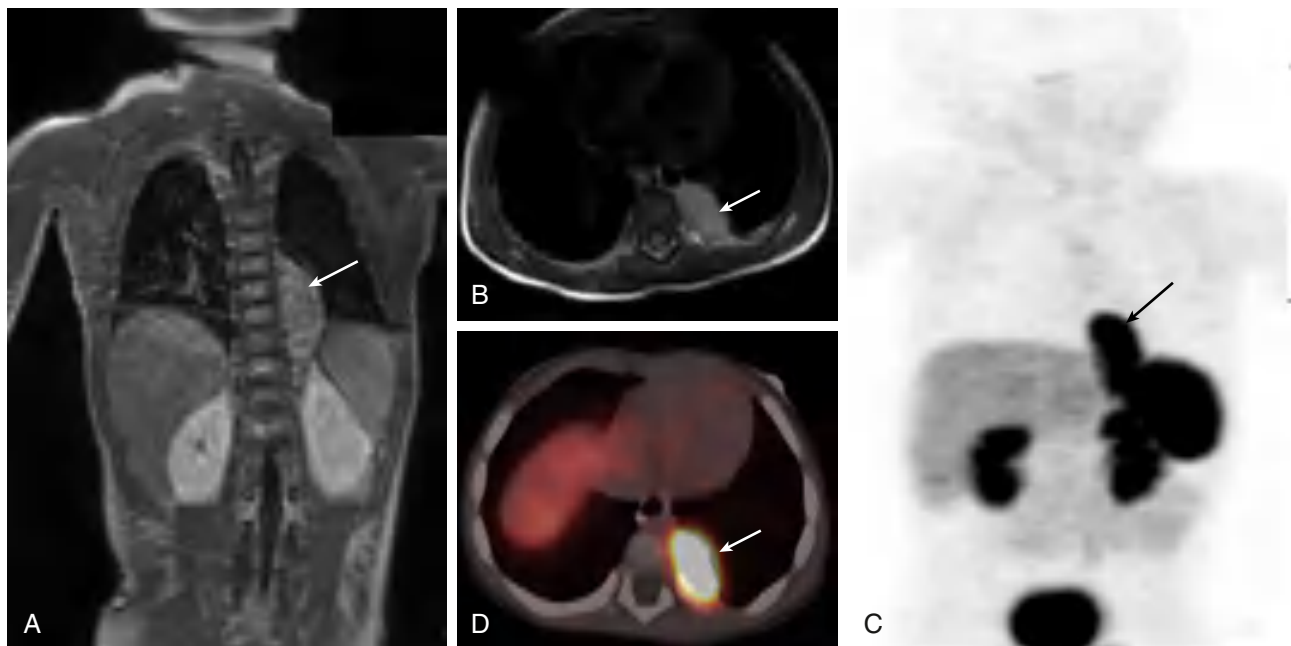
Neuroblastoma. MRI and gallium-68 DOTANOC PET/CT scan of chest and abdomen reveal a mass in left posterior mediastinum (likely neuroblastoma). A, Coronal T1-weighted postcontrast image (A) and axial T2-weighted image (B) reveal a well-defined isointense lesion ($42 \times 26 \times 27$ mm) in the left posterior mediastinum extending from D7–D11 vertebrae. C, PET/CT maximum intensity projection image shows increased uptake in left lower thoracic paraspinal region. D, Axial fused PET-CT image shows somatostatin-receptor expressing mass (maximum standardized uptake value, 21; arrow in A–D) in the same location. (From Kaur A, Bhagwat C, Madaan P, et al. Dancing eyes. *J Pediatr*. 2019;214:231.)
